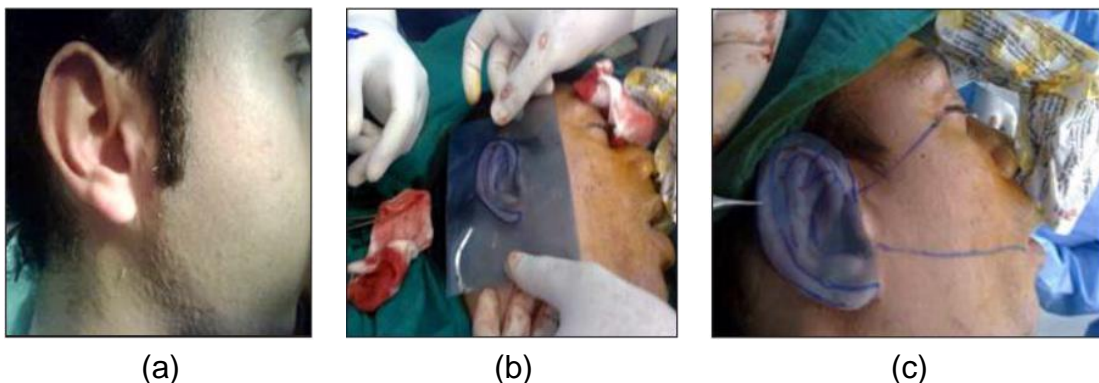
(a) Normal side of patient. (b) Radiographic film on normal side. (c) Orientation of normal ear to canthus of the eye and corner of the mouth [14].
